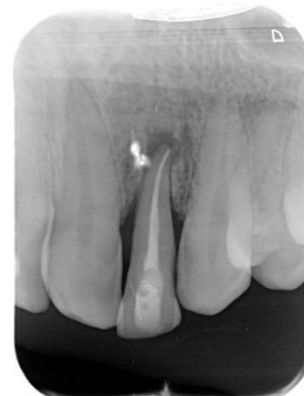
the three-month radiograph recall.
